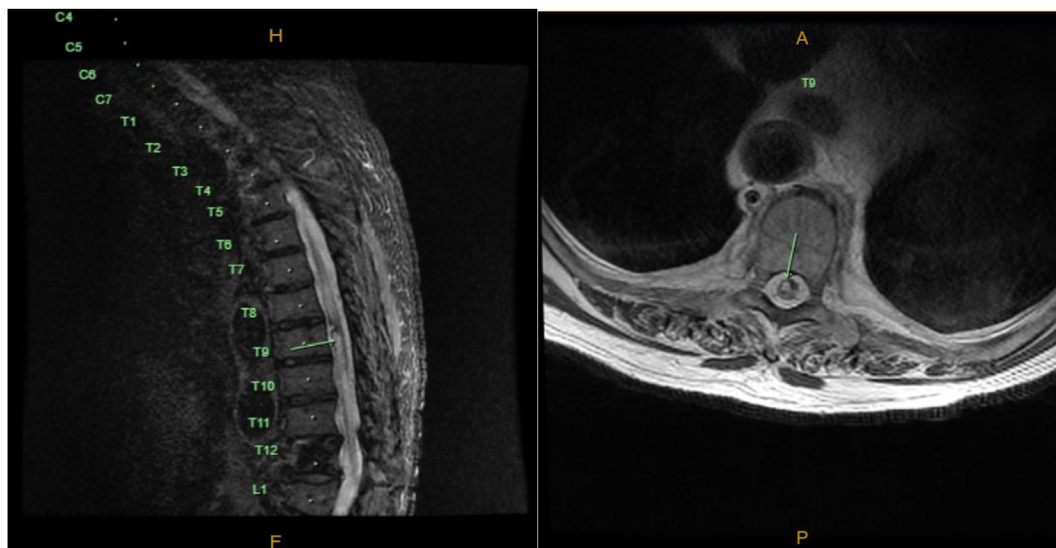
MRI demonstrating cavernous malformation in Short Tau Inversion Recovery sagittal and T2 axial views.
